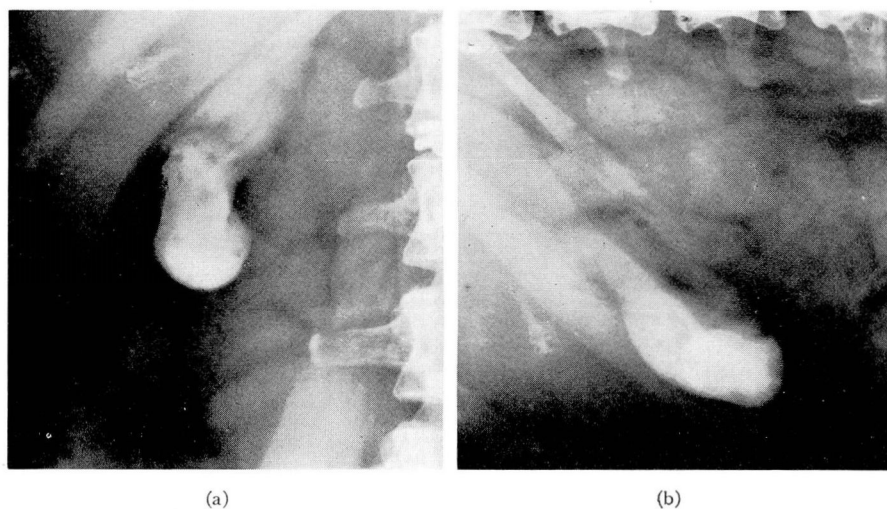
Multiple papillomata. (a) Posteroanterior prone roentgenogram showing multiple nonopaque shadows. (b) Posteroanterior lateral decubitus roentgenogram. The nonopaque shadows have not settled or layered but remain in the same constant position with respect to gallbladder as in (a).
